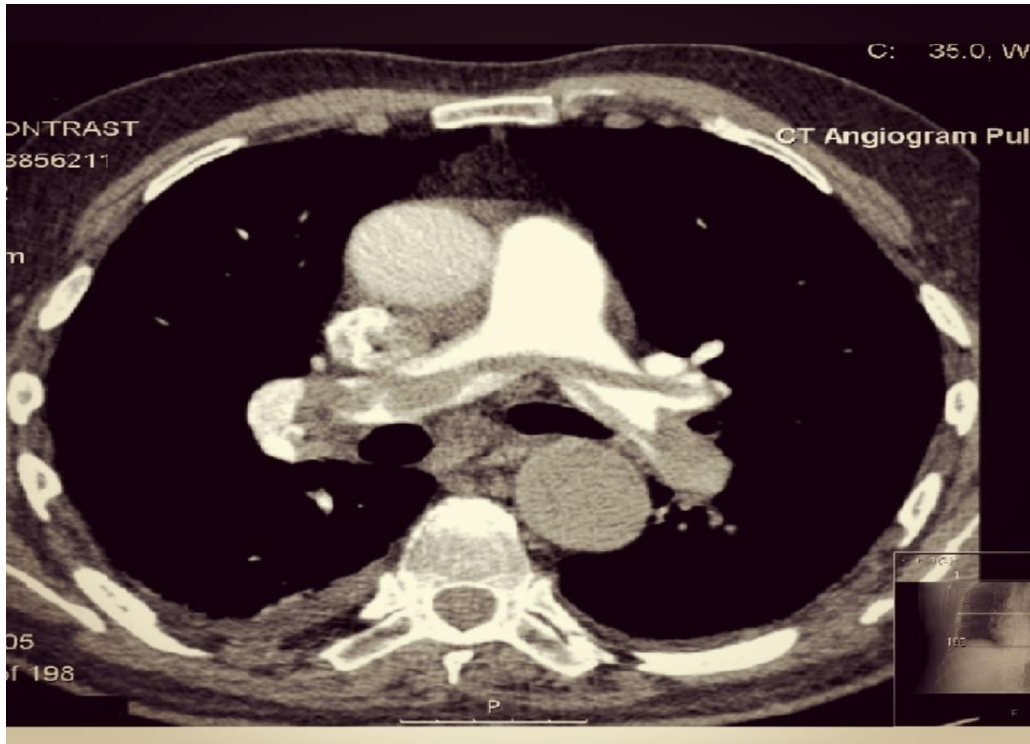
patient have chest pain and severe dyspnea 60 years male, this image showing large intra-luminal filling defect (saddle PE). Axial CT scan.
